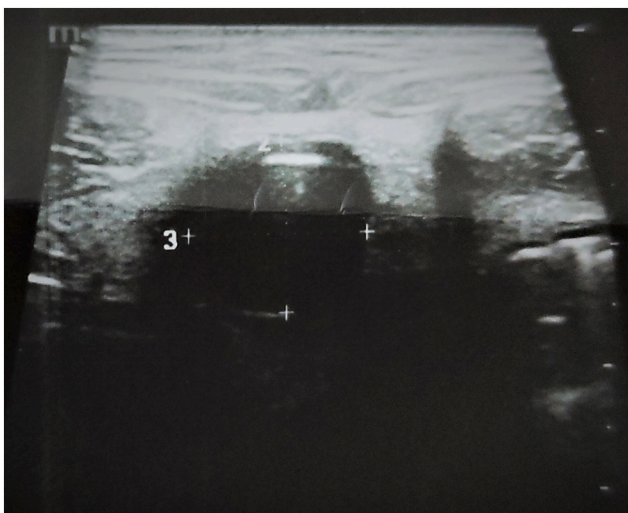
Ultrasound scan image showing the urachal cyst.
